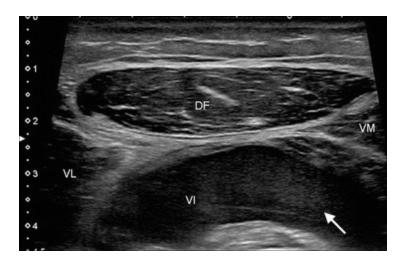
Transverse ultrasound image at the mid third of anterior thigh shows severe anechoic signal within the vastus intermedius due to collected hematoma. *DF* rectus femoris, *VI* vastus intermedius, *VL* vastus lateralis, *VM* vastus medialis, *fe* femur
